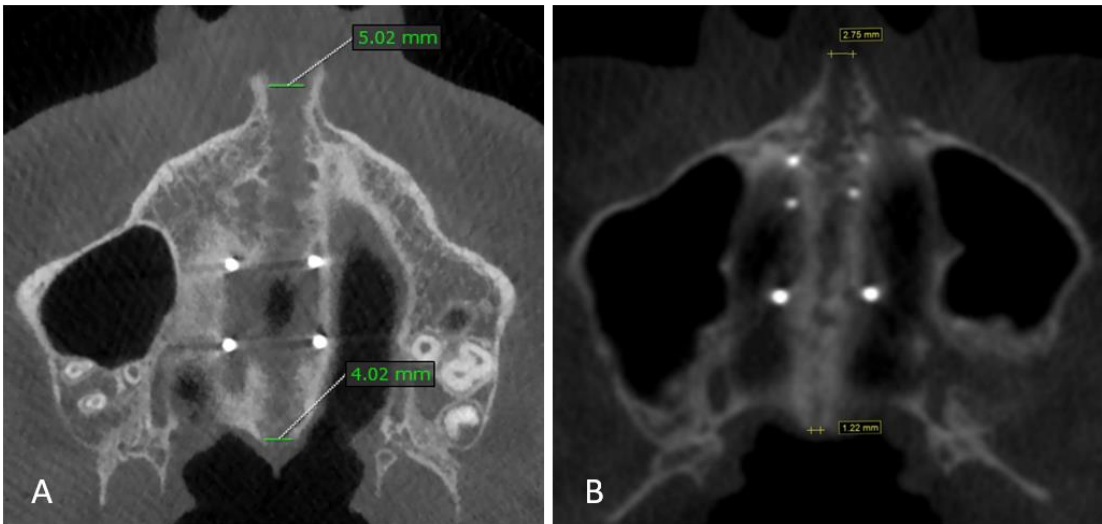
Post-expansion CBCT showing the pattern of midpalatal suture split with non-surgical MSE with additional miniscrews placed laterally on the palatal side of alveolar process between second premolar and first molar (A) and anteriorly to MSE body (B). In (A) the midpalatal suture split is more parallel (ratio of split at PNS / split at ANS is 80%) than in (B) (ratio of split at PNS / split at ANS is 44%)⁶⁶.
